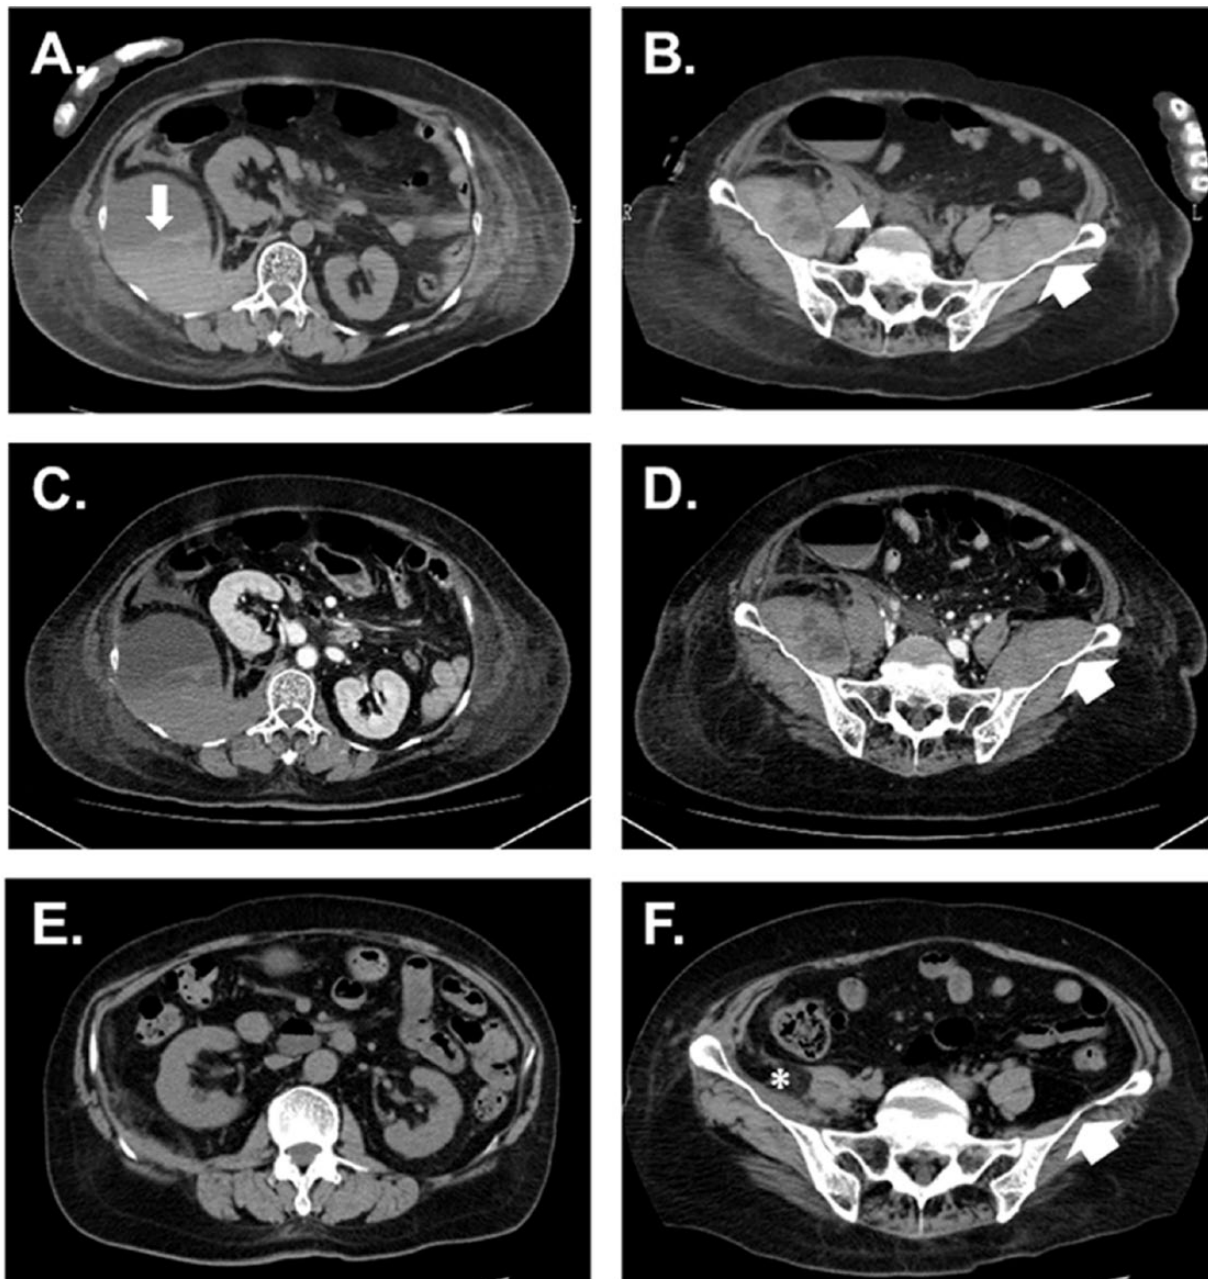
(A, C, and E) The findings of a diagnostic computed tomographic (CT) scan at L1 and (B, D, and F) the top of the sacrum. A noncontrast CT scan demonstrates a huge right-sided retroperitoneal collection with a hyperdense dependent layer (arrow in A), whereas the ipsilateral iliac muscle is shown to contain a fluid-fluid interface as well (arrowhead in B). (C and D) No seeping of the contrast material is demonstrated by a subsequent contrast-enhanced CT scan. (E and F) A distinct reduction in the size of the right iliac muscle (asterisk in F) as well as resolution of the right-sided hemorrhagic lesion was shown on repeat CT performed on clinical day 164. Note that there is a marked reduction in the size of the left iliac muscle as well (wide arrows in B, D, and F).
